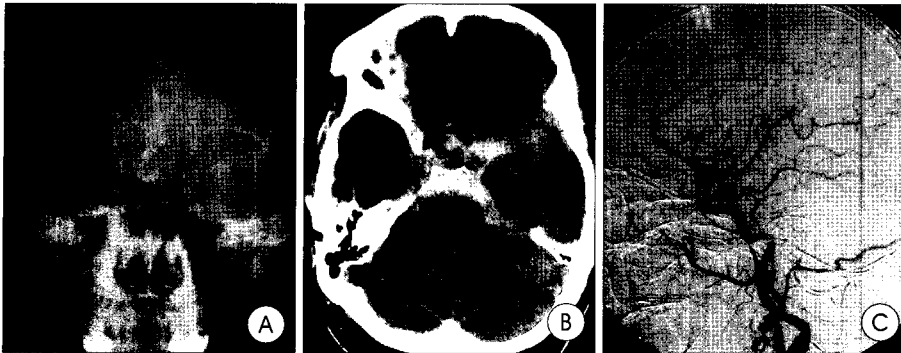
A : Preoperative skull anterior-posterior view showing a prominent frontal sinus (black arrow). B : Non-contrast computed tomography axial image showing a thick subarachnoid hemorrhage in the basal cistern. C : Cerebral angiography showing a saccular aneurysm on the posterior communicating artery, left posterolateral direction, 10-mm in size.
